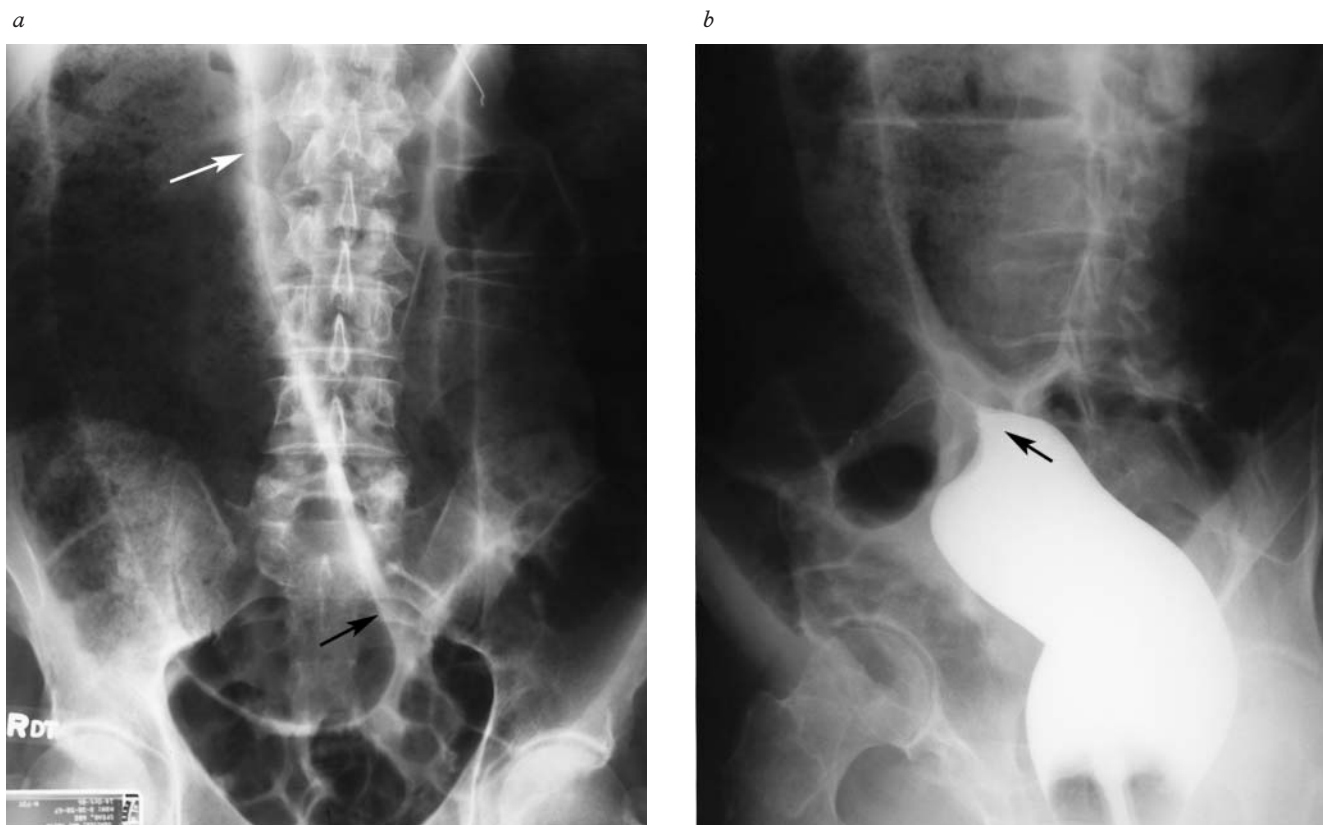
(a) Radiograph from a patient with massive sigmoid volvulus shows a distended ahastral sigmoid loop (*white arrow*), inferior convergence of the walls of the sigmoid loop to the left of the midline, and approximation of the medial walls of the sigmoid loop as a summation line (*black arrow*). (b) Barium enema of the colon shows a tapered obstruction at the rectosigmoid junction with a typical bird's beak deformity (*black arrow*).
